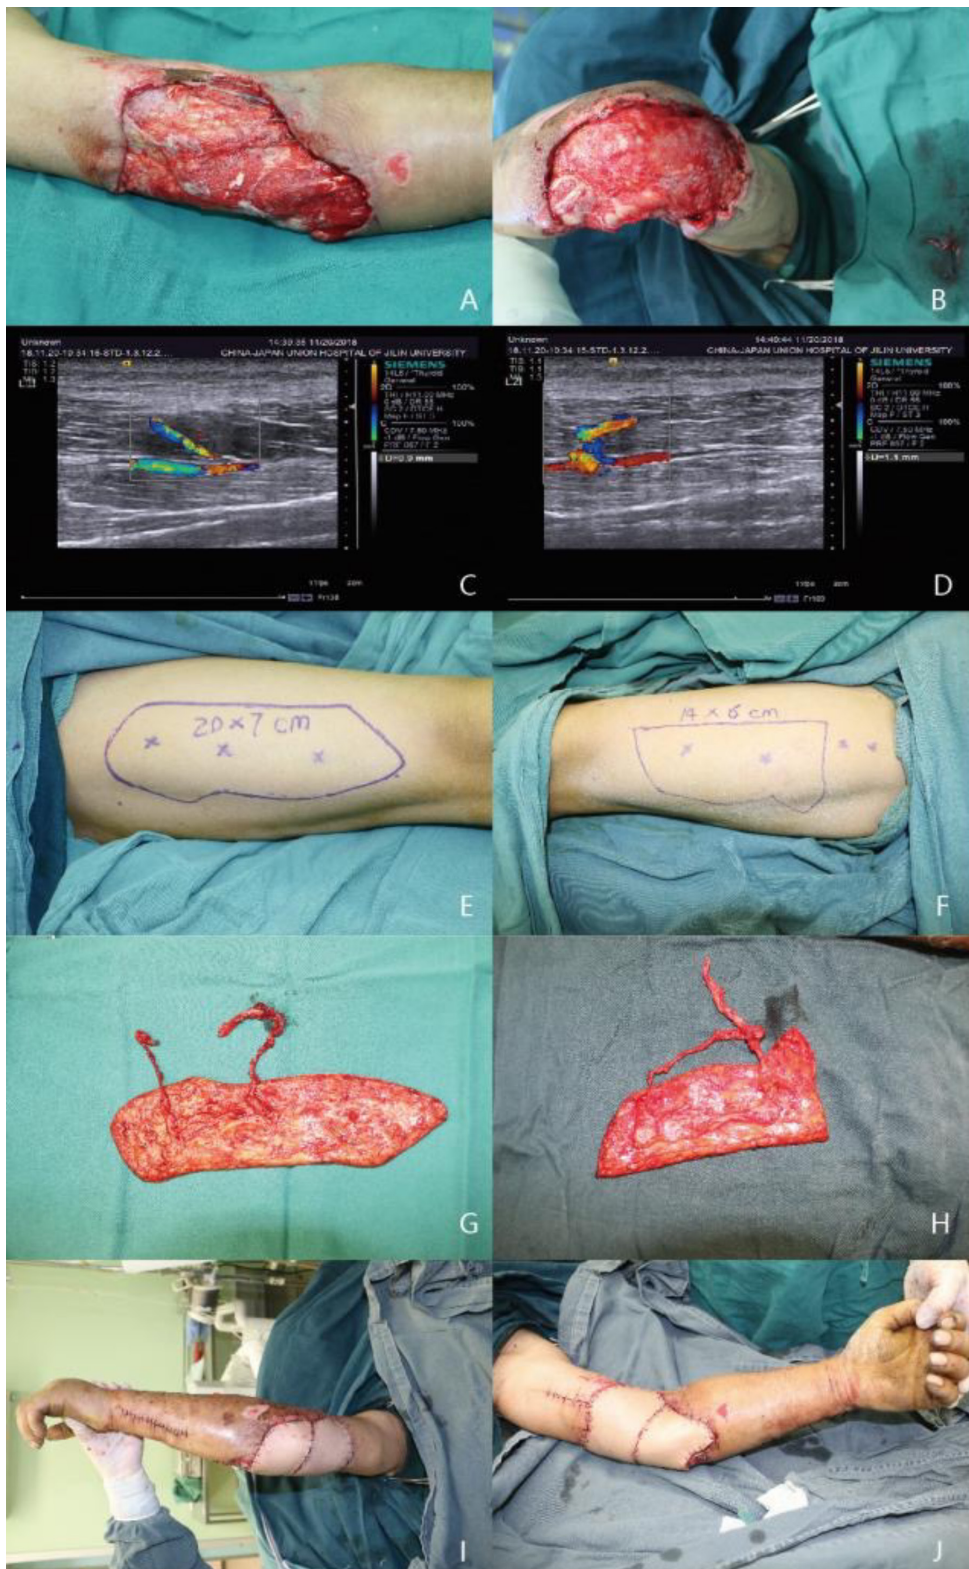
A-B, Large skin and soft tissue defect of the left elbow and upper arm before the operation. C-D, The location of the perforator using preoperative color Doppler ultrasonography. E, Design of a free anterolateral thigh perforator flap on right thigh (size: 20.0×7.0 cm²). F, Design of a free anterolateral thigh perforator flap on left thigh (size: 14.0×6.0 cm²). G, The right proximal perforating branch coming from the transverse branch of the lateral circumflex femoral artery, and the distal end coming from the descending branch of the lateral circumflex femoral artery. H, The perforating branches of the left anterolateral thigh perforator flap coming from the descending branch of the lateral femoral circumflex artery. I-J, Successful coverage of the defect was achieved.
